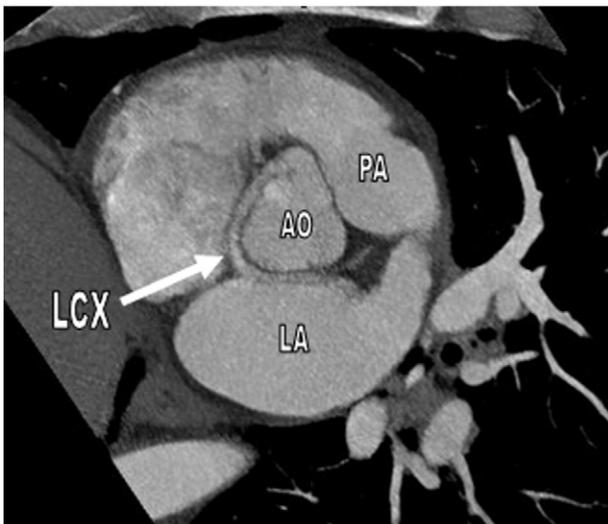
Axial image of MSCT coronary angiography shows retroaortic course of LCX (MSCT: Multislice computed tomography).
